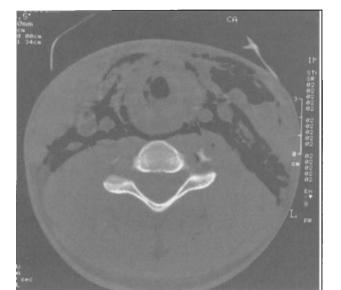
CT scan of the neck demonstrating extensive subcutaneous emphysema.
